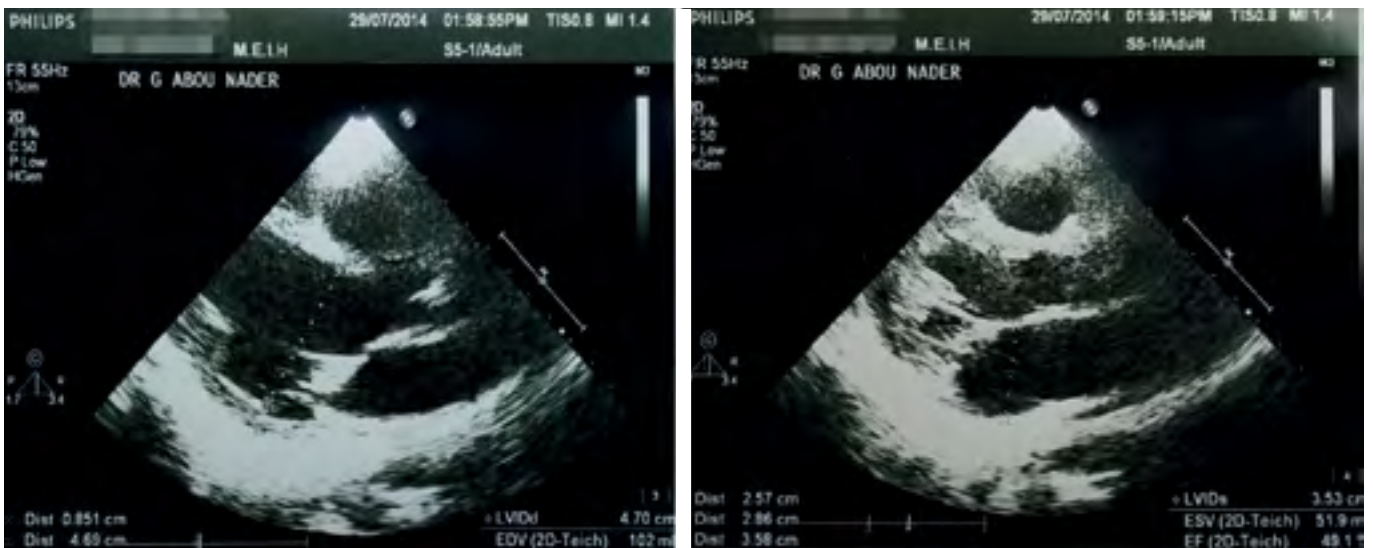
Left parasternal long axis view of the resting Echocardiogram, showing a good contractility of the myocardium with an Ejection Fraction (EF) of 49.1%, and a Left Ventricular Internal Diameter end systole (LVIDs) of 3.53 cm ©EKaram
